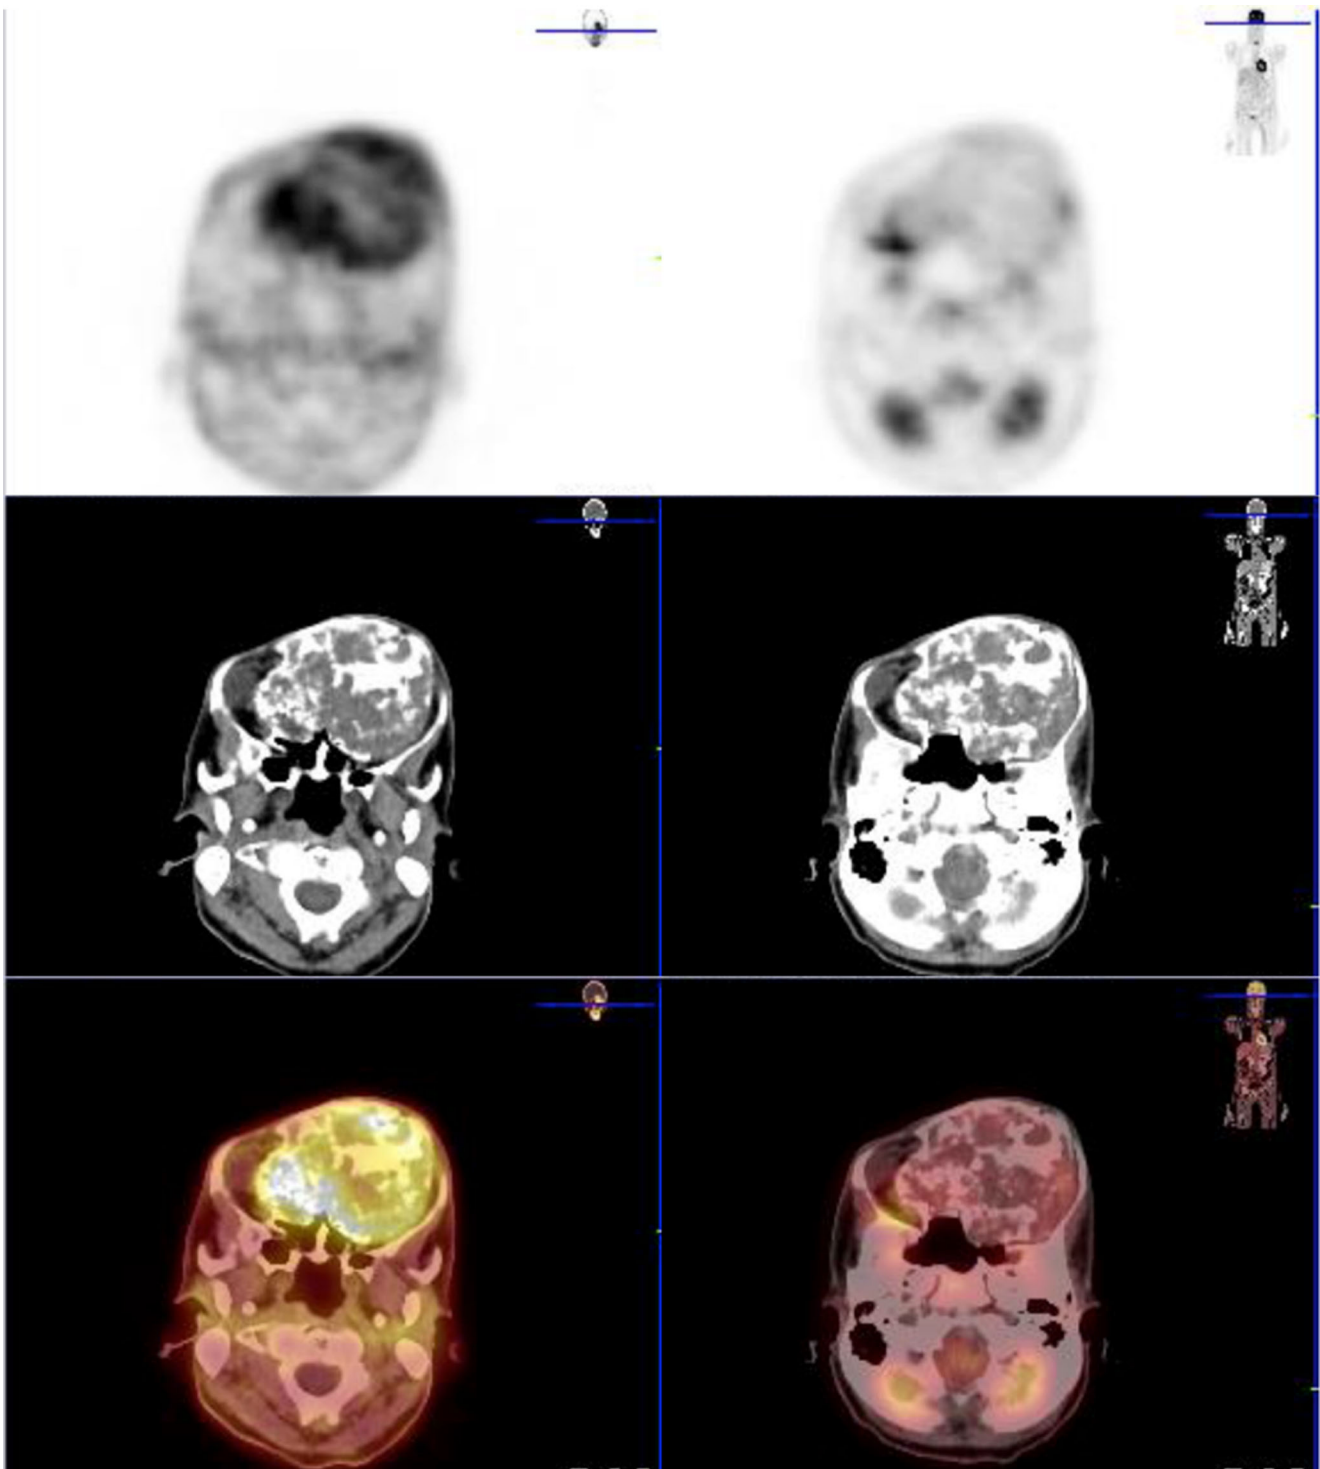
This 32 year old male underwent both ^{18}F -FDG and ^{68}Ga -RGD PET/CT for suspected recurrence following complaints of new-onset bone pain. He had completed chemotherapy and radiotherapy following surgical excision of the left frontal bone tumour which confirmed Chondroblastic Osteosarcoma. ^{18}F -FDG images on the right demonstrate no uptake in the left sided skull lesion whereas ^{68}Ga -RGD images are discordant with ^{18}F -FDG findings. Noninvasive PET imaging of integrin $\alpha\text{v}\beta 3$ with ^{68}Ga -arginine-glycine-aspartic acid (^{68}Ga -RGD) has become an important tool for tumour diagnosis and treatment
